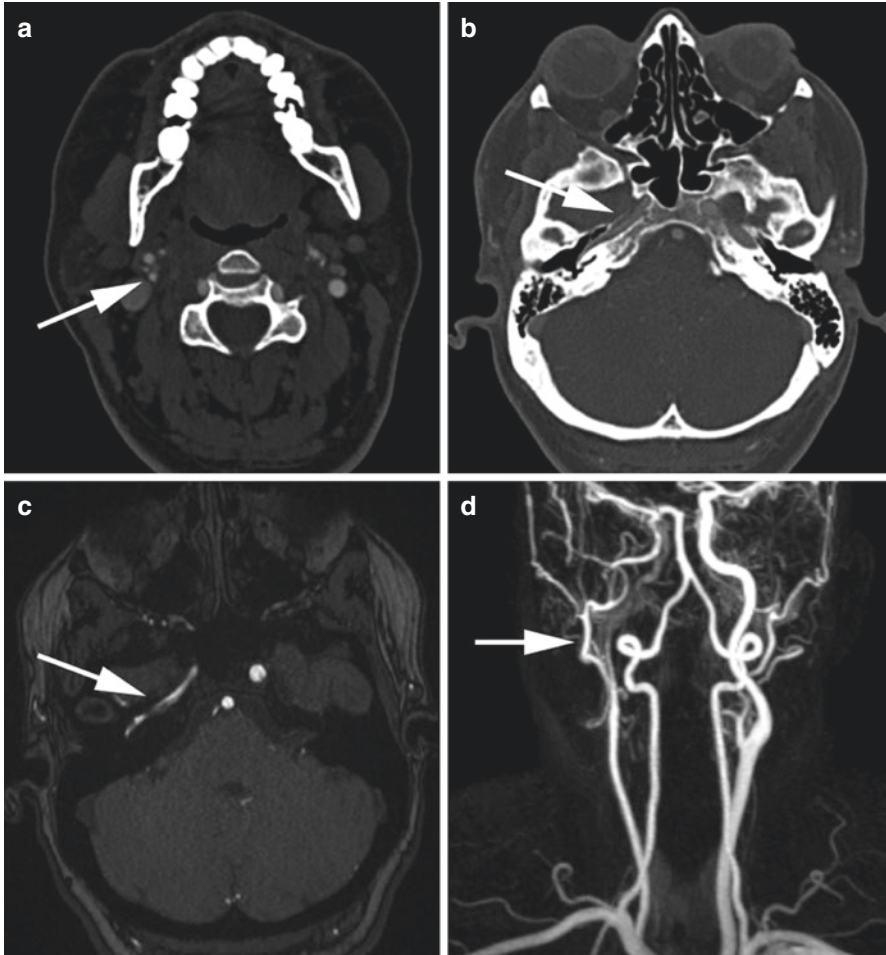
Aberrant internal carotid artery. Patient with an aberrant right ICA. CTA showed an enlarged right-sided ascending pharyngeal artery (a, arrow) that coursed along the cochlear promontory with an asymmetrically small carotid canal (b, arrow). The ascending pharyngeal artery supplied an enlarged inferior tympanic artery, caroticotympanic artery, and then connected with the posterolateral aspect of horizontal petrous ICA. MRA with TOF (c) and contrast maximum intensity projections (d) confirmed an aberrant right ICA (arrow)
